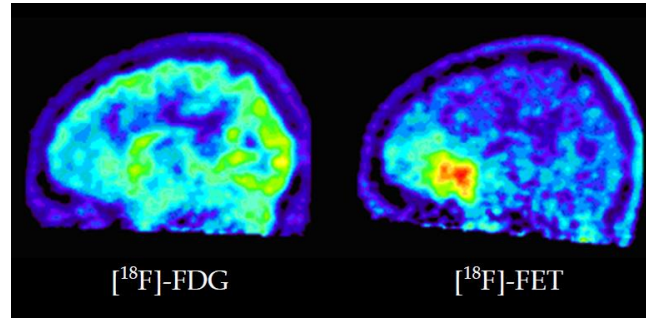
$[^{18}\text{F}]$ -FDG and $[^{18}\text{F}]$ -FET PET contrast images, showing higher tumour-to-background contrast with FET. Adapted from [43].
